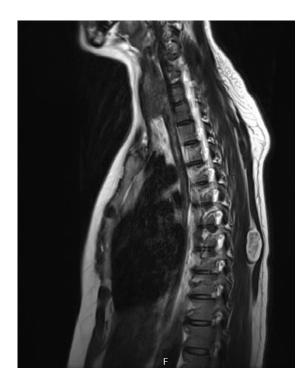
The appearance of the mass in the sagittal plane T2 in the magnetic resonance imaging
